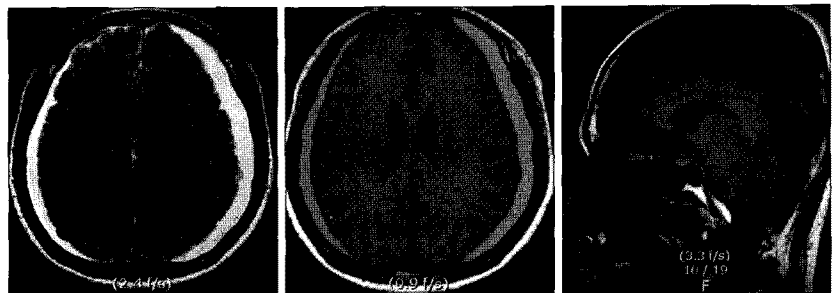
Follow-up MRI of brain obtained 9 days after conservative treatment shows that bilateral supratentorial subdural and retroclival extradural hematomas remained unchanged in size compared with previous film.
